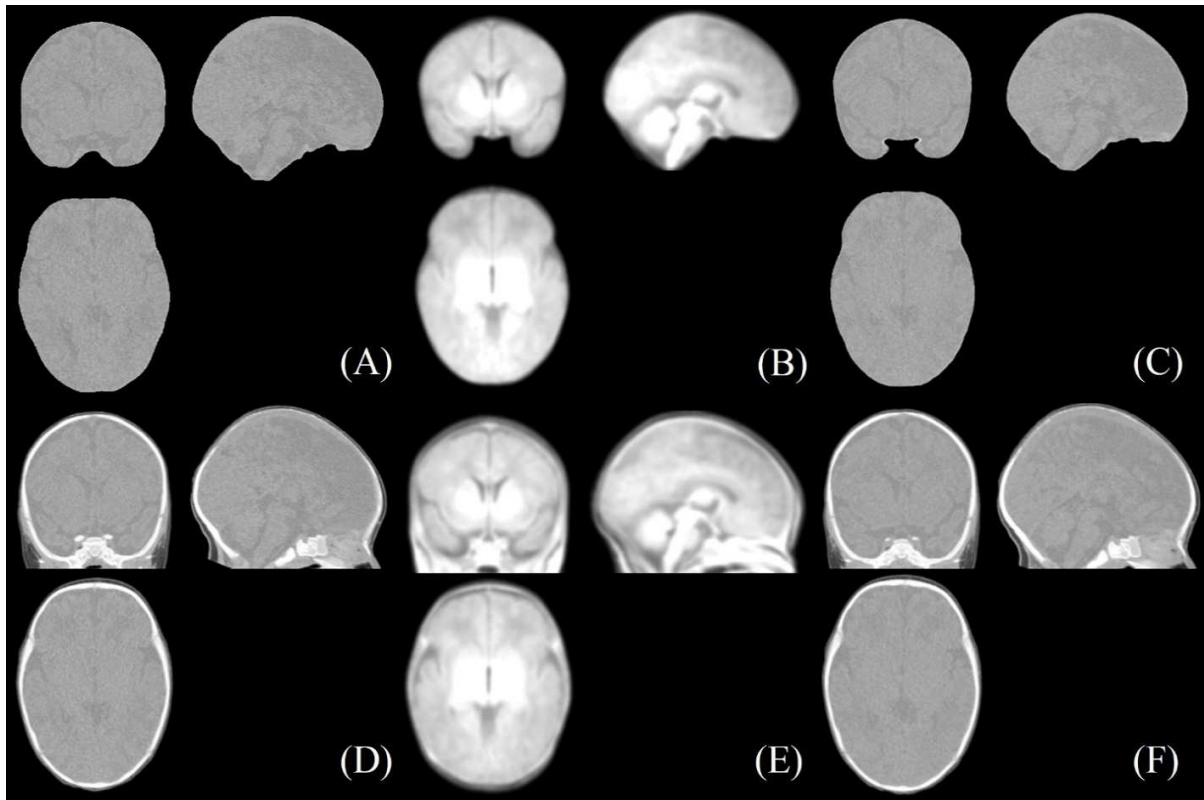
Mapping CT image to neonatal MR template. (A) CT image intracranial, (B) MR intracranial template [13], (C) Normalized CT intracranial to MR intracranial using affine and non-linear SyN transformation [25], (D) CT' image obtained by applying the resulting deformation field from normalizing (A) to (B) to the whole intensity transformed preprocessed CT image, (E) GRAMFC_T₃₉₋₄₂ MR template [19], (F) Fully registered CT image to MR template obtained by linearly registering (D) to (E).
